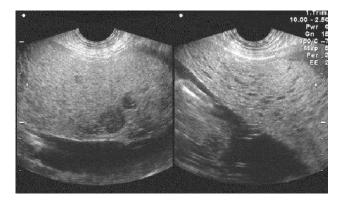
Ultrasound image showing a molar placenta in the right panel with part of the normal fetus (nourished by a second placenta). The left panel shows molar cavitations in the placenta. Image courtesy of B. Caspi
